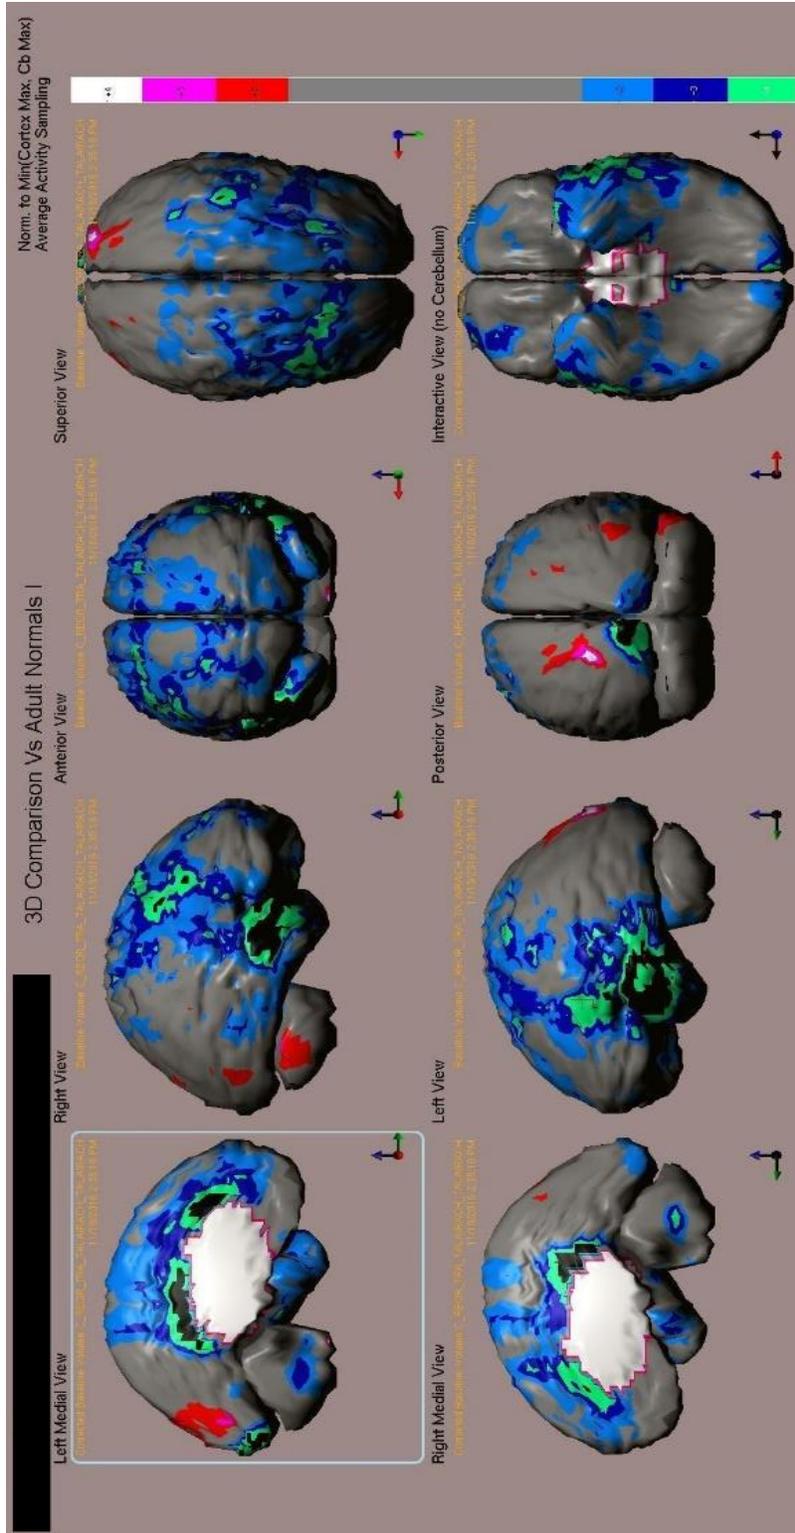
Modern SPECT imaging using cutting edge Segami Oasis software provide much higher resolution, detailing the patchy diffuse vascular hypoperfusion characterizing the ME/CFS brain (Hyde, 2017).
